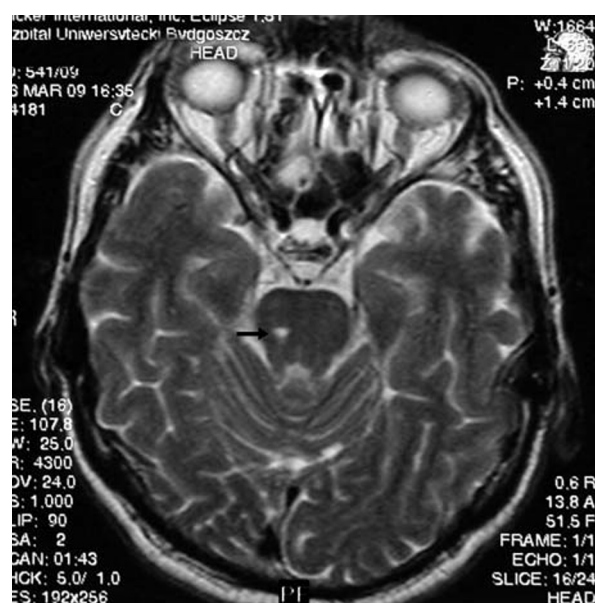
Magnetic resonance imaging of the head showing a focus of a vasogenic lesion, 0.5 cm in diameter, in the upper part of the pons on the right side
